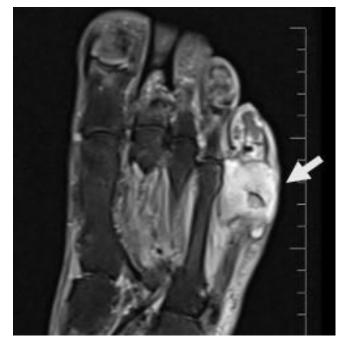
MRI of the foot
